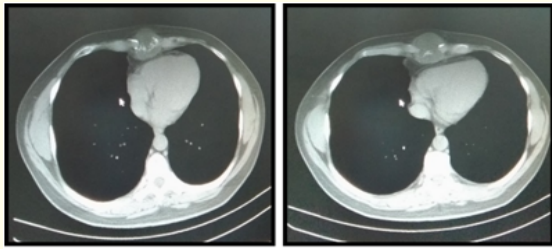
CT scan showing sternum tumor.
